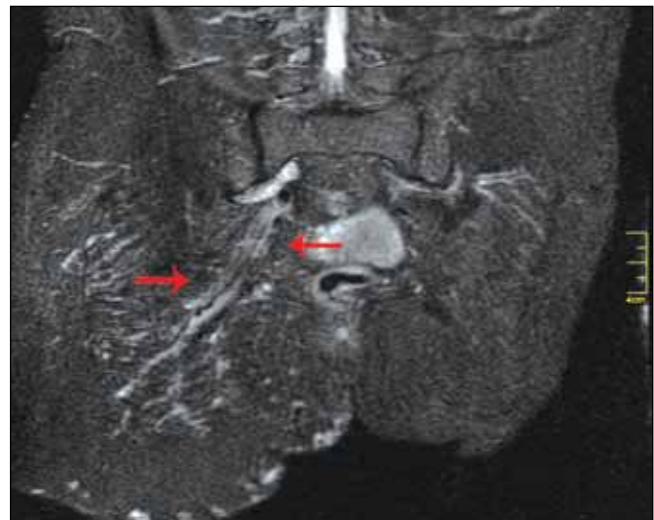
Sciatic nerve hypertrophy in hip MRI.
